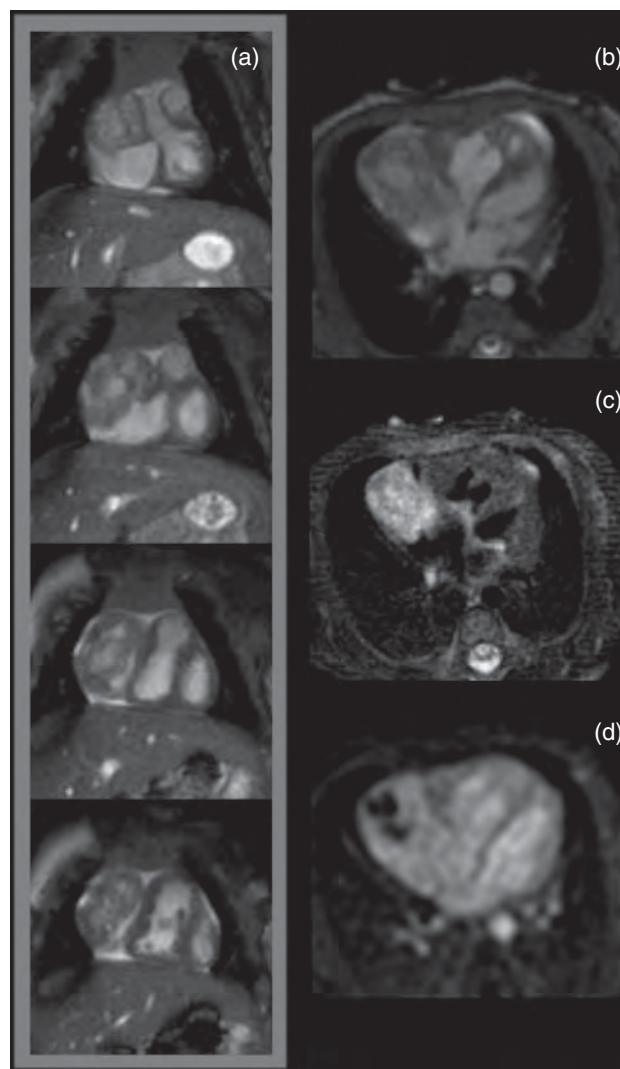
CMR images of a right atrial hemangioma causing mild right heart compression with (a,b) an inhomogeneous appearance corresponding to either vascular channels or cysts by CMR; (c) a hyperintense appearance on T2-weighted imaging consistent with increased fluid content; and (d) profound enhancement on first pass perfusion imaging with the exception of a central dark area, likely corresponding to cysts.
